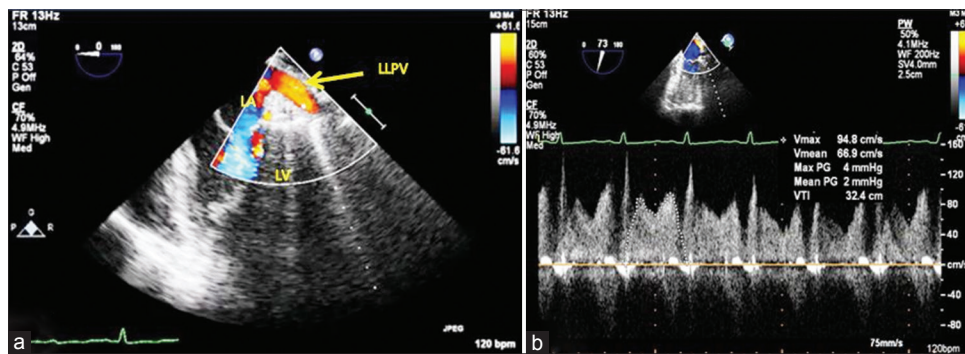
Transesophageal echocardiography. (a) Mid esophageal left lower pulmonary vein view and (b) pulsed wave Doppler of left lower pulmonary vein showing peak velocity of 0.8 m/s. LA: Left atrium, LV: Left ventricle
